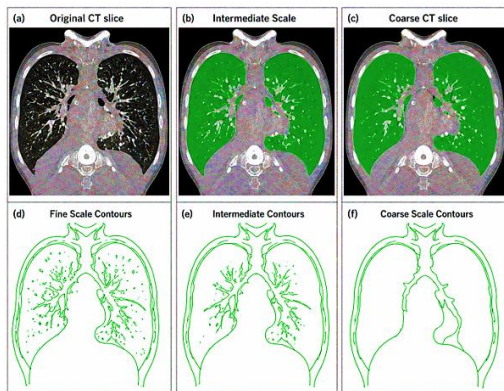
Multiscale TV flow segmentation on lung CT: fine, intermediate, coarse scales.
